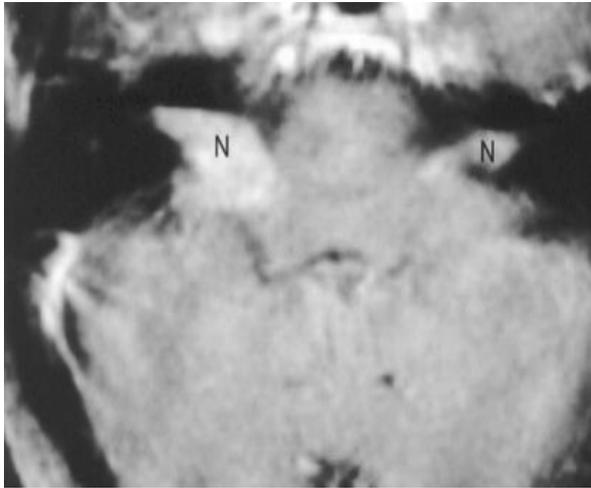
Axial MRI, T1 sequence with intravenous contrasted agent showing bilateral enlargement and enhancement of both facial and vestibulo-cochlear nerves (N) more prominent on the right side.
